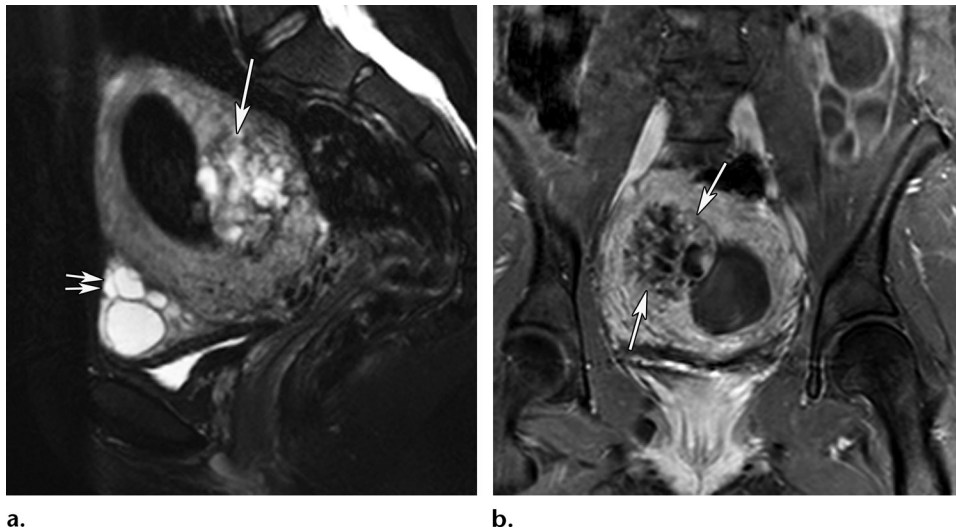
Invasive molar pregnancy at 10 weeks gestation. (a) Sagittal T2-weighted image shows a large mixed solid and cystic mass (long arrow) extending from the endometrium into the myometrium. Note the multiple theca lutein cysts in the ovaries (short arrows). (b) Axial (through the uterus) contrast-enhanced T1-weighted image with fat suppression shows a heterogeneously enhancing mass (arrows) extending from the endometrium into the myometrium.
